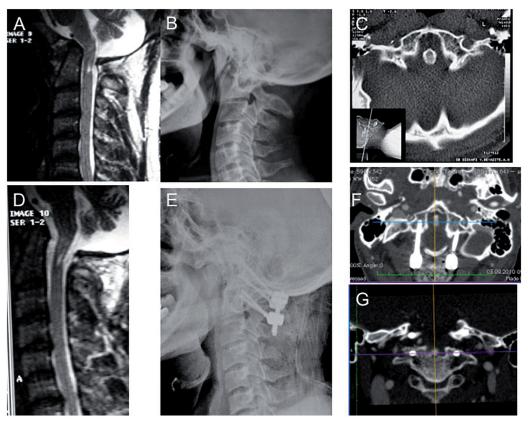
A 39-year-old man presented with paresthesia and weakness in all four limbs. Preoperative sagittal MRI (A), lateral radiograph (B) and axial CT scan (C) and indicated severe medulla compression with AAD and Bl. C1/C2 joint reduction technique and C1 lateral mass and C2 pedicle screw fixation technique was performed. Post-operative sagittal MRI (D) and lateral radiograph (E) showed complete reduction of the deformity with C1 lateral mass and C2 pedicle screw fixation with joint reduction technique. Post-operative axial CT scan through the C1 level (F) shows bilateral C1 lateral mass screws (F) and coronal CT scan (G) shows bilateral C1 lateral mass screws in the occipitalis atlas and bilateral C2 pedicle screw fixation technique.
